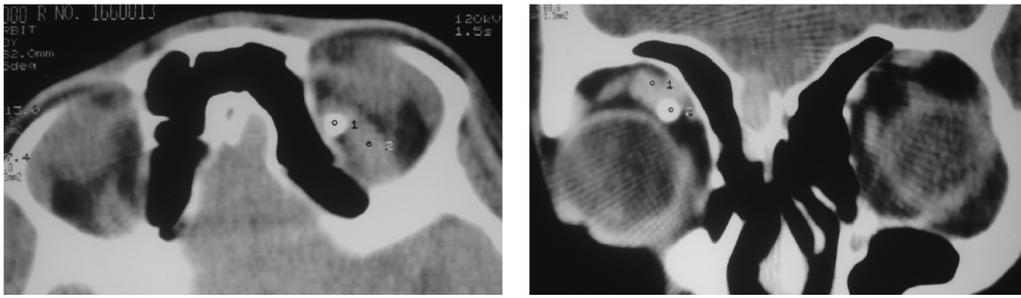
Orbital hemangioma with phlebolith on CT
